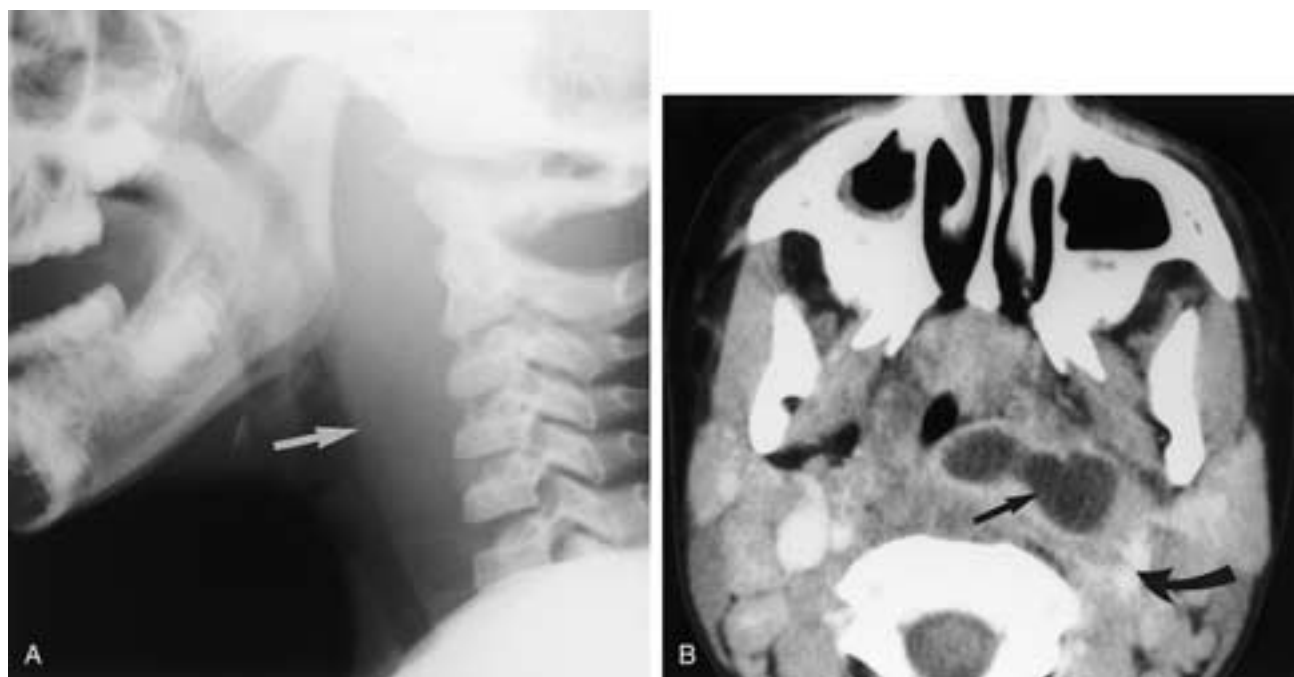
Retropharyngeal abscess in a 4-year-old boy. A, Lateral plain film reveals marked widening of the retropharyngeal soft tissues (*arrow*). Compare this appearance with that in [Figure 29-65A](#). B, Contrast-enhanced CT reveals a large low-attenuation, ring-enhancing left retropharyngeal abscess (*arrow*) with distortion and narrowing of the airway. There is lateral displacement and attenuation of the left carotid artery and internal jugular vein (*curved arrow*).
